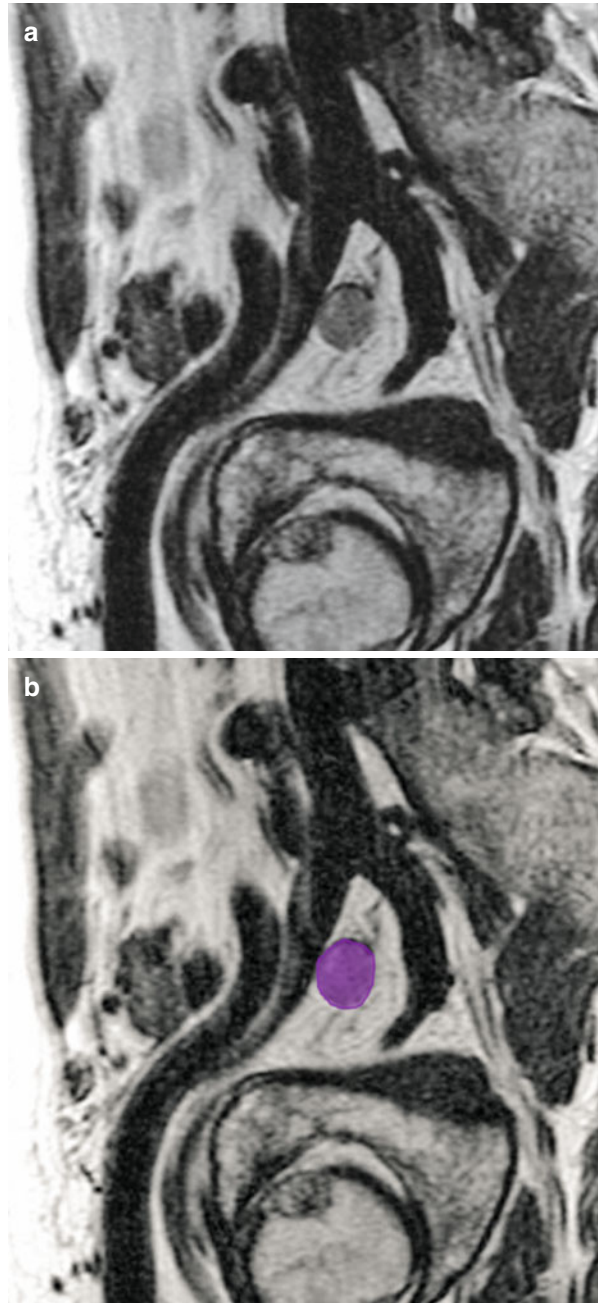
(a, b) Oblique sagittal T2-weighted MR image shows metastatic obturator lymph node (*purple*) in a patient with prostate cancer
